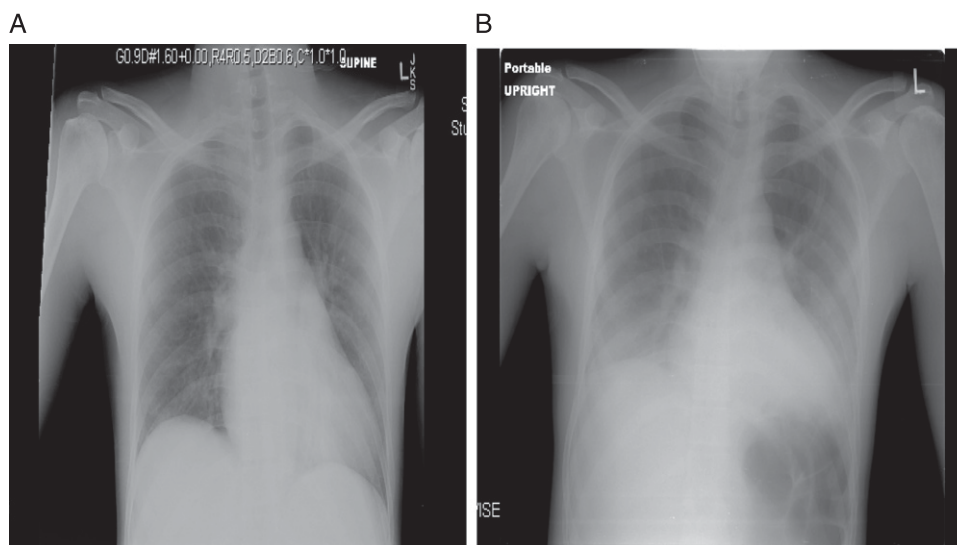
Portable chest radiograph of case patient. A, Initial chest radiograph. B, Chest radiograph 12 h later.
